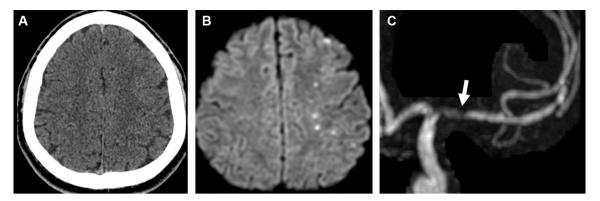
Thirty-two-year-old man presenting with fever and seizures. Normal CT-scan. (A). Small focal hyperintensities in left frontal lobe on DWI. (B). Proximal stenosis left middle cerebral artery on TOF-MR angiography (C).
